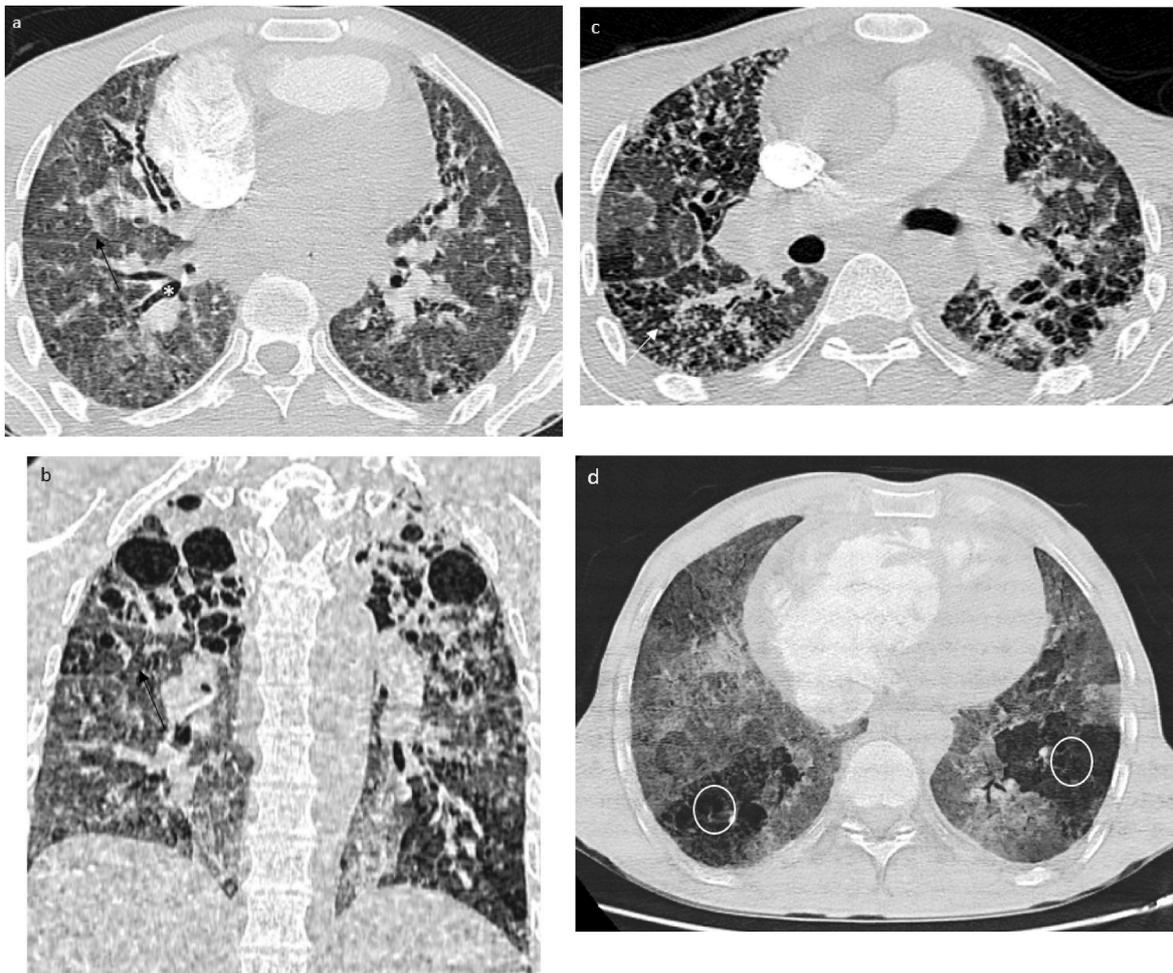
A 55-year-old man with COPD follow-up contrast-enhanced axial (a,c) and coronal (b) chest CT images in lung window, 5 months after initial presentation, showing extensive residual pulmonary opacities alongside with architectural distortion. Note the disruption of the normal course of the right oblique fissure (Black arrow), associated traction bronchiectasis (*), and extensive honey-combing (White arrow). A mosaic attenuation pattern (White circles) in lower lung lobes best demonstrated on mIP reconstructions using narrow window parameters (d).
